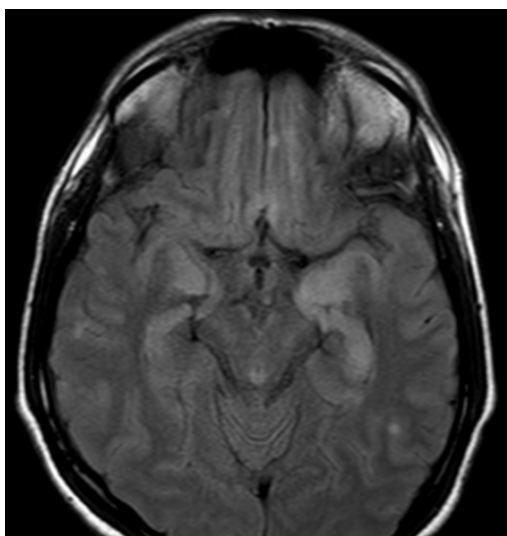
Symmetrical FLAIR Hyperintensities in Bilateral Medial Temporal Lobes
